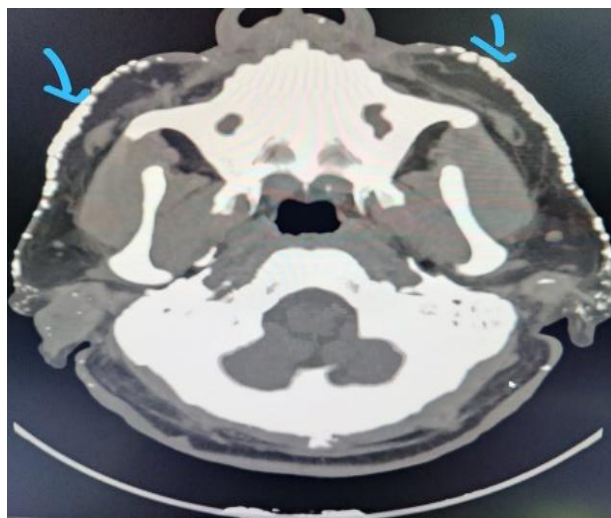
CT scan of the head showing high-attenuation foci (arrows) in the subcutaneous tissues of both cheeks, indicative of calcinosis cutis, with no surrounding edema or inflammation.
